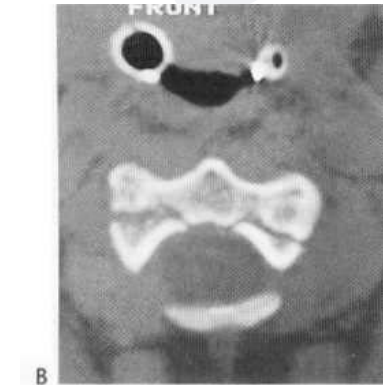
Low (Type III) odontoid fracture. (A) The lateral radiograph demonstrates interruption of the radiographic 'ring' of the body of C2 (arrows). (B) CT demonstrates the nature of the fracture, through the body of C2.
